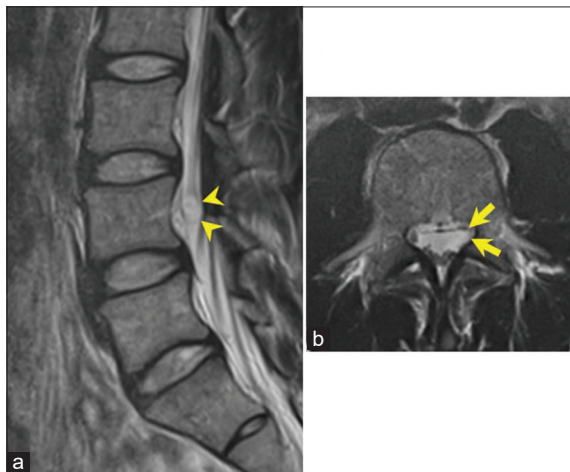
Preoperative magnetic resonance images. (a) T2-weighted image showing a high-intensity small tumor (arrowheads) at the L4 level. (b) Axial T2-weighted image at the L4 level showing absence of the L4 nerve root (arrows).
